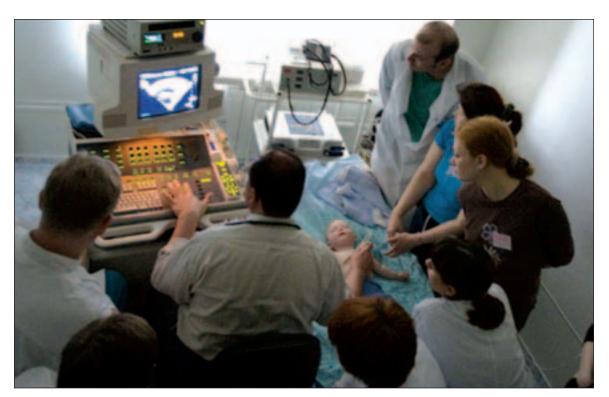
Dr Cetta demonstrating echocardiography in a patient with congenital heart disease to health care workers in Russia. Photo by Joye Photography.
